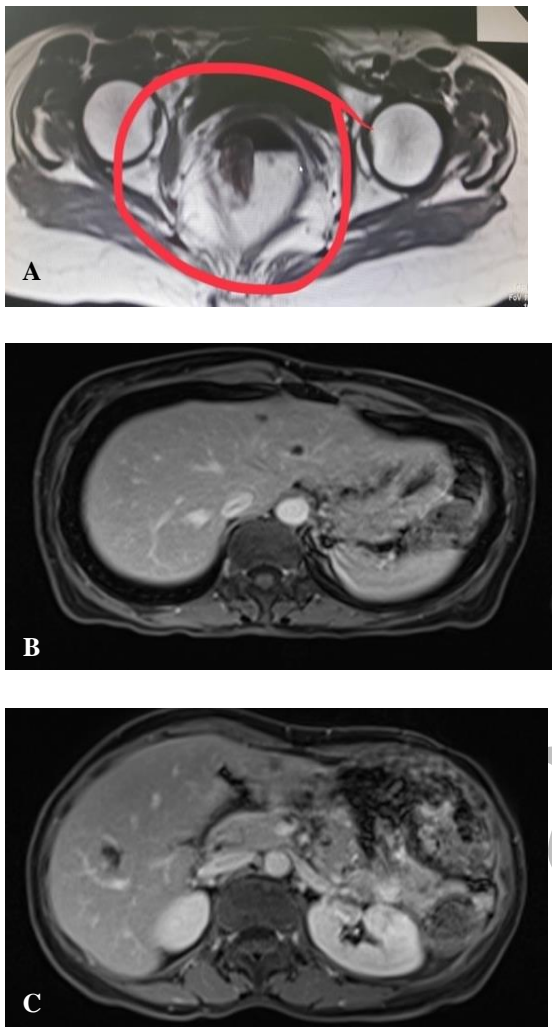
Initial magnetic resonance imaging of abdomen and pelvis in the axial plane showing: (A) on post-contrast T1w sequence, a tumor mass located in rectum, penetrating all layers of the poster wall and infiltrating perirectal fat up to 30 mm, expanding to the mesorectal fascia bilaterally (mrT3d stage, MF+) (B) and (C) on post-contrast T1FSw sequence, cysts and hemangiomas in the liver (no metastatic lesions)
